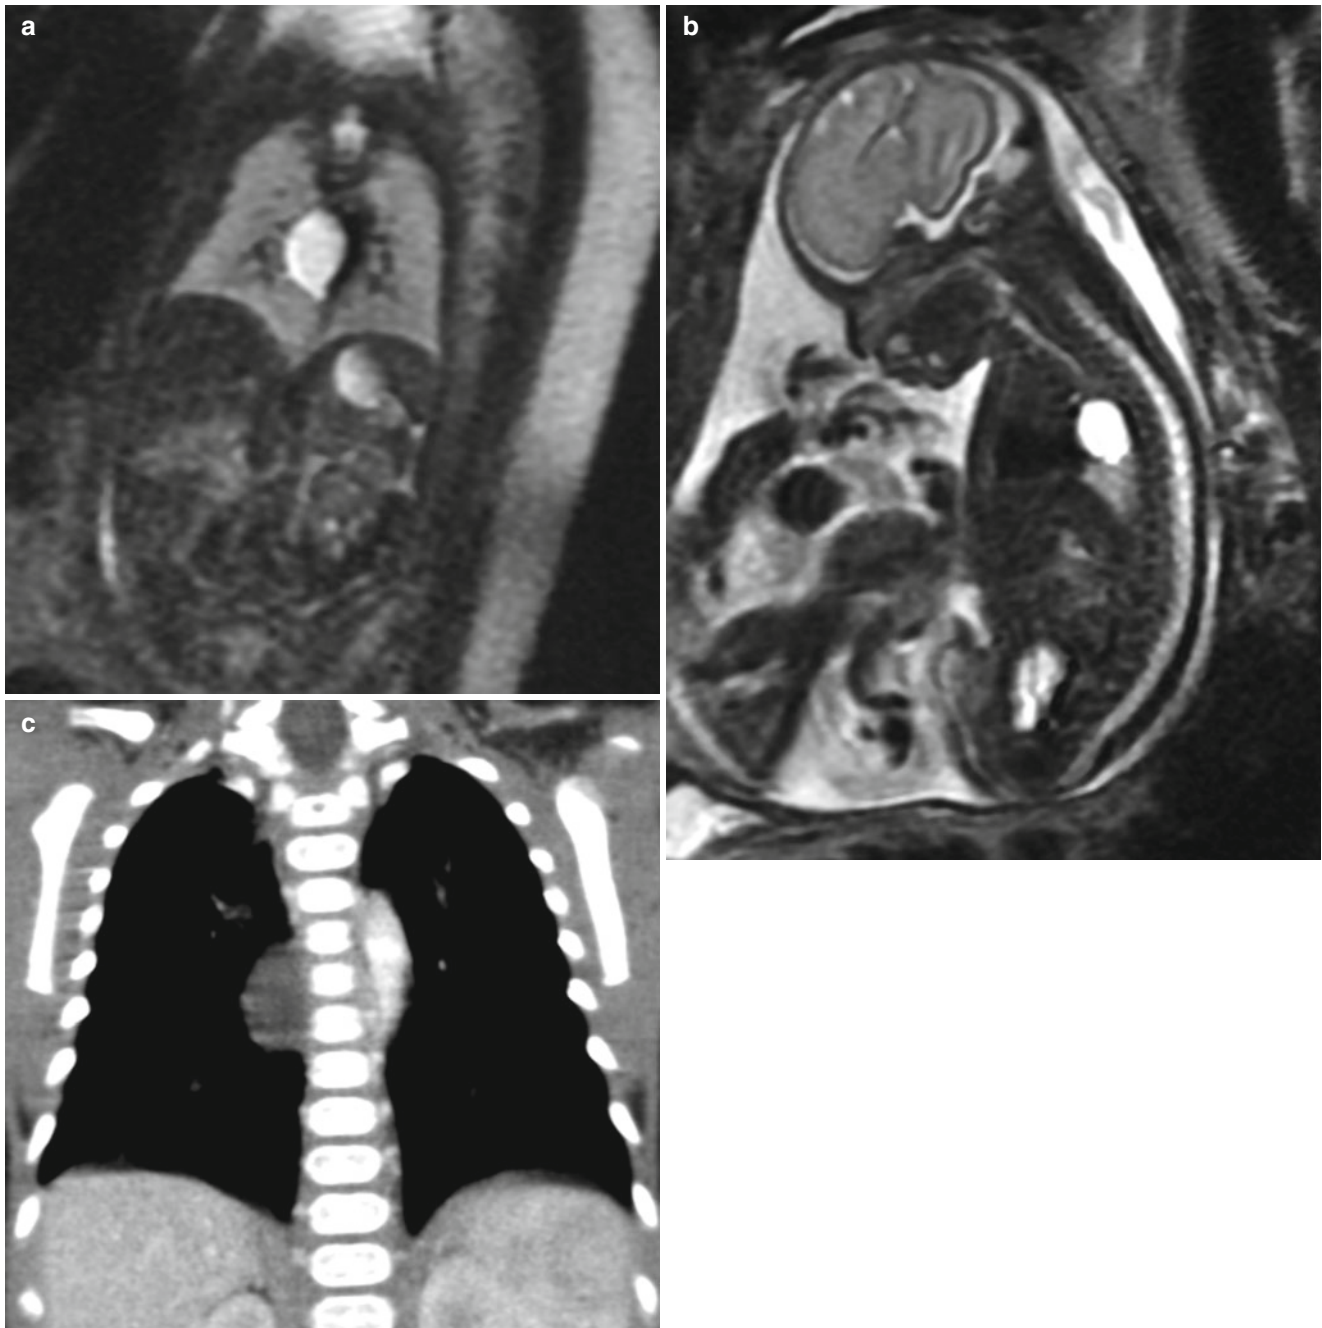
Bronchogenic cyst. Coronal (a) and sagittal (b) SSFSE T2w images of the chest demonstrate a high-signal cyst in the middle mediastinum. The lung parenchyma appeared normal. (c) Postnatal CT confirms the presence of a bronchogenic cyst
